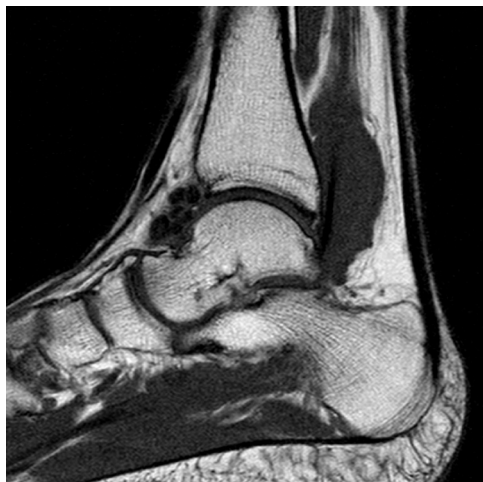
The loose bodies are demonstrated on the anterior aspect of the ankle joint in the sagittal T1-weighted MRI.
